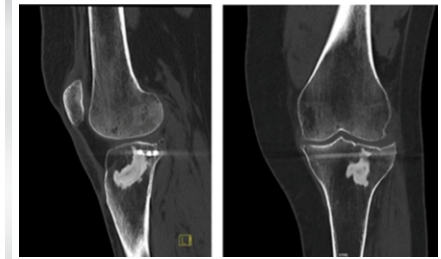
Six-year follow-up CT scan with osteointegration of Cal cemex visible. (Credits – Andrea Pizzoli et al.).
